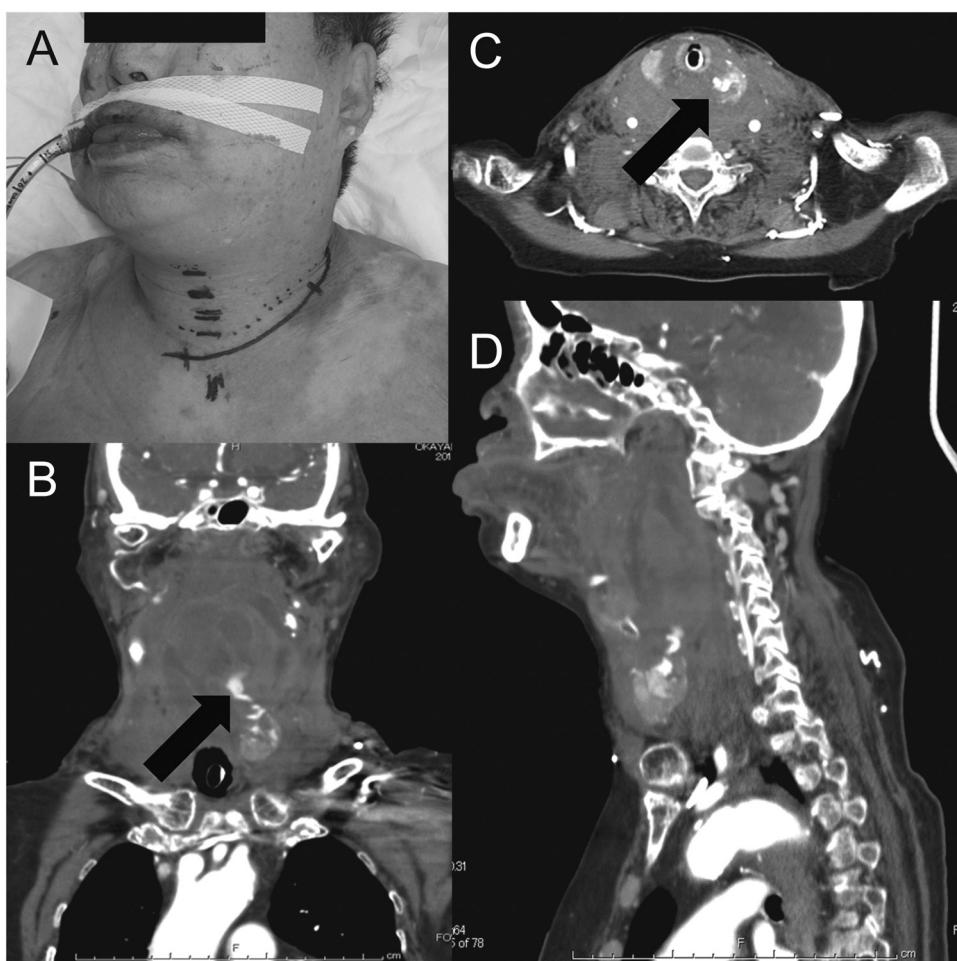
Swelling in the anterior neck area prior to surgery (A). Contrast-enhanced CT demonstrated left thyroid gland lobe rupture with an extensive hematoma reaching from the thyroid to the mediastinum. An extravasation from the left thyroid artery was noted (arrow, B and C). Widening of the retropharyngeal and retrotracheal space with right deviation of trachea were noted (D).
